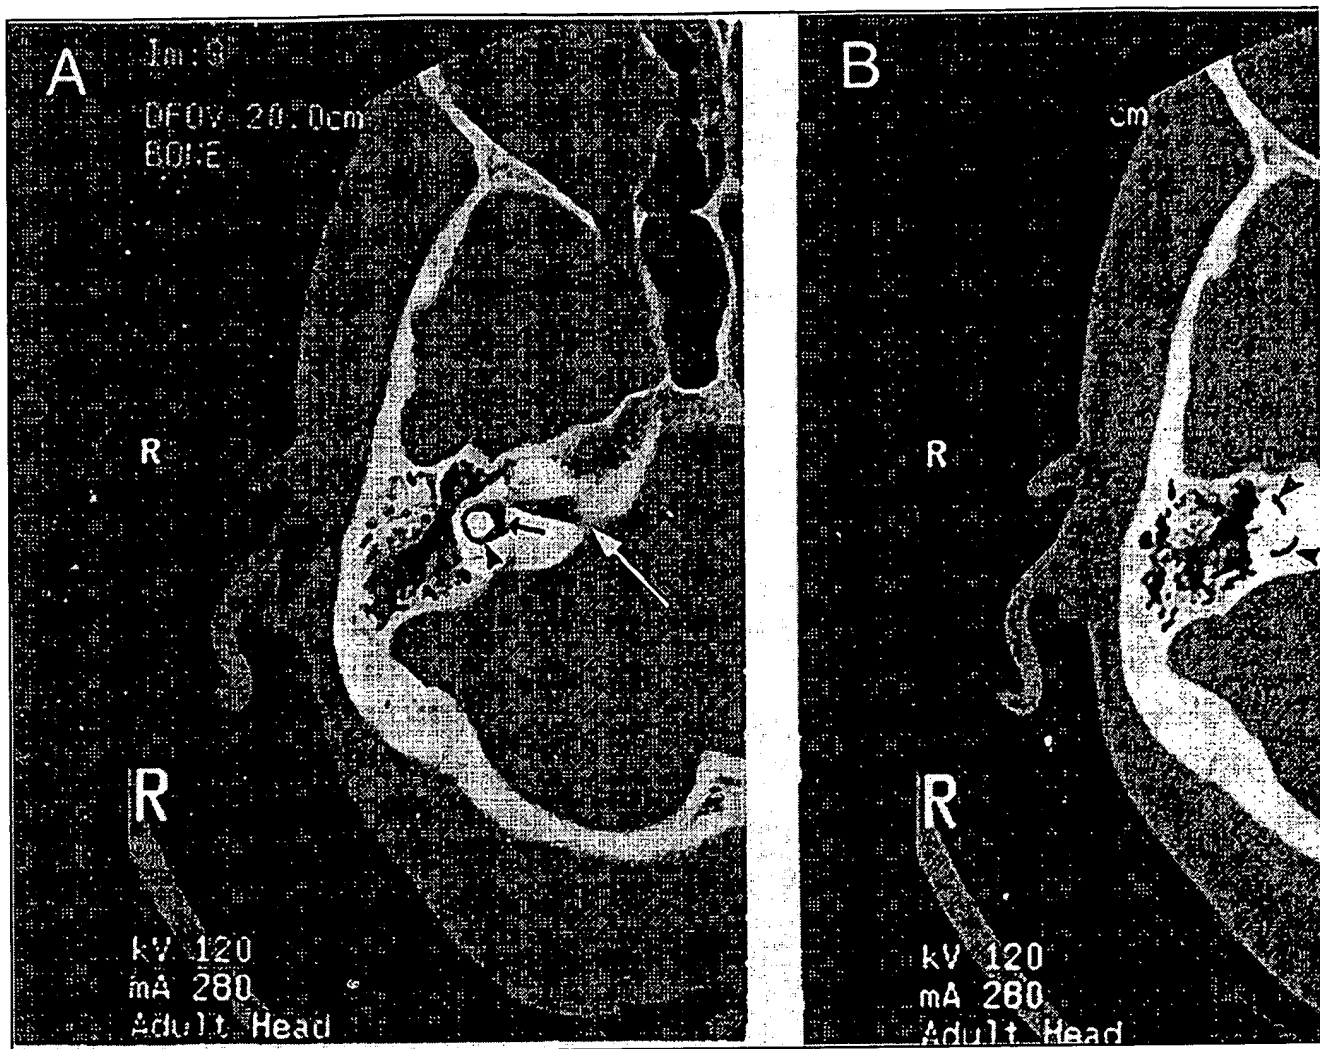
Computed tomography (CT) scans of the human temporal bone. The horizontal (A, arrowhead) posterior (B, arrow heads) semicircular canals, utricle (A, small arrow), and internal acoustic canal (A, large arrow) are visible.
